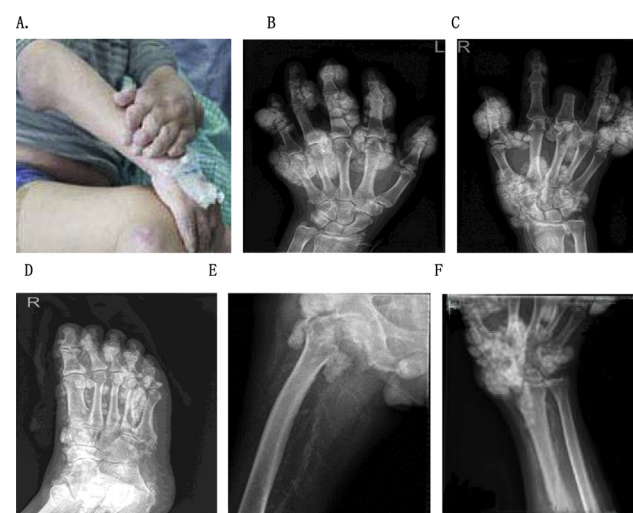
A. Multiple juxta-articular masses near bilateral elbow joints, wrist joints, metacarpophalangeal joints, interphalangeal joints, toe joints and knee joints. B, C, D, E, F. X-ray manifestations: mass-like calcification shadows in the peripheries of multiple joints all over the body; subcapital fracture of right femur; linear calcification of middle and small arteries of limbs, calcification of reticular vessels.
